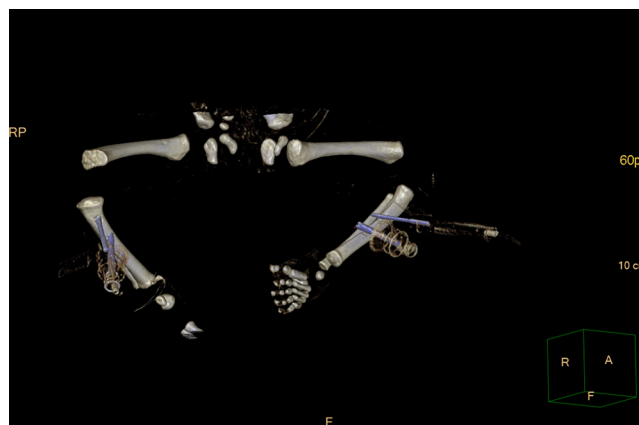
Postmortem computed tomography (CT) of a preterm stillborn infant, age 27 + 4 gestational weeks demonstrating the dislocated installation of the intraosseous needles on the right tibia and correct installation on the left one (proximal Butterfly needle and distally located hand-twisted EZ-IO® intraosseous needle).
